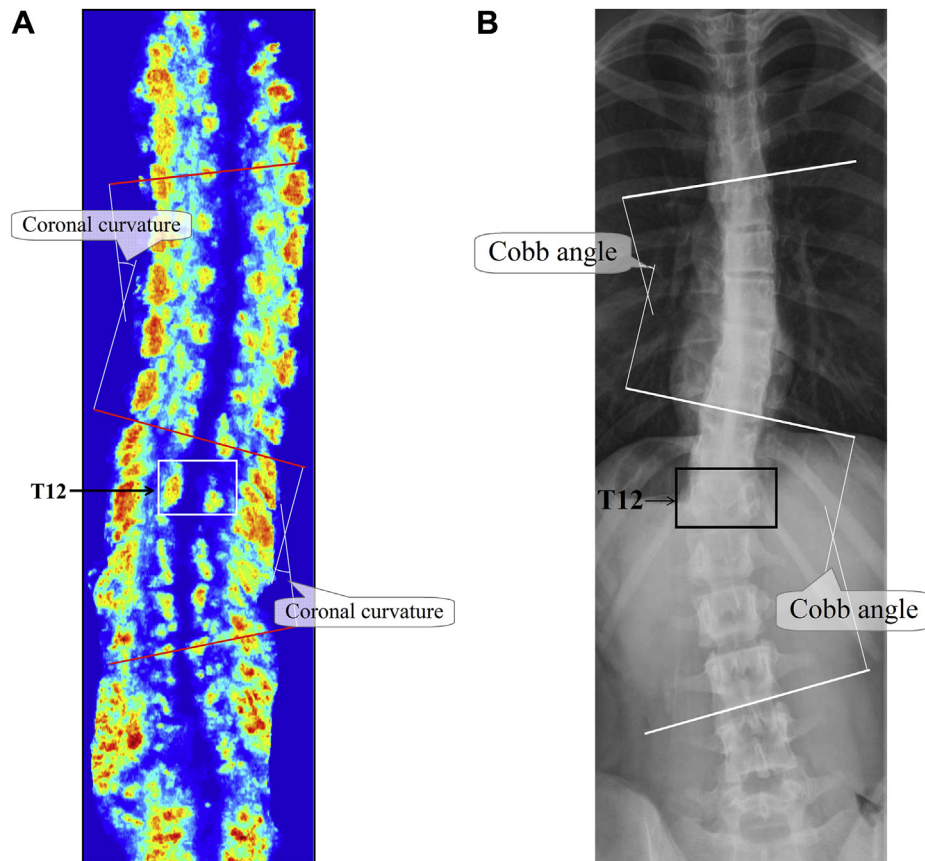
Curvature measurement: (A) using the center of laminar method on ultrasound image in the coronal plane and (B) using the Cobb method on radiograph.
